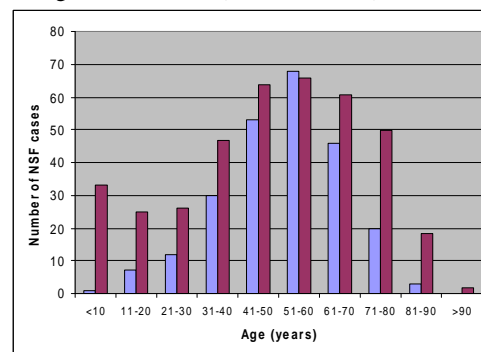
Incidence of NSF by Age. For 240 NSF cases, the number of patients in each decade are shown in blue. The age distribution for 39,166 MRI examinations at local hospital is shown in pink. Note that the peak incidence is in the 40-60 range with virtually no cases in the first decade of life and a dwindling incidence for age > 60 years.
